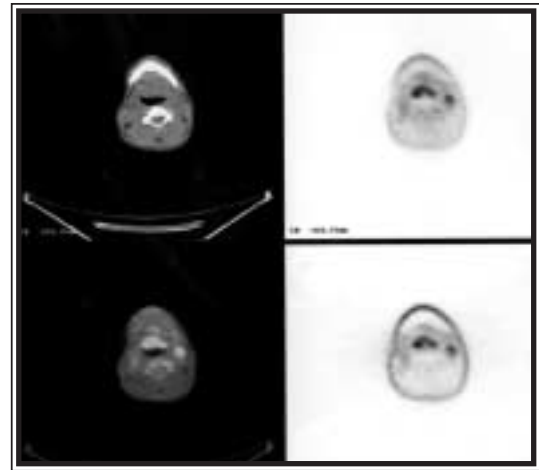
CT scan alone is unrevealing, while PET scan shows intense uptake but is unable to localize tumor adequately. Integrated PET/CT shows intense FDG uptake in the vallecula, indicating a supraglottic cancer.
